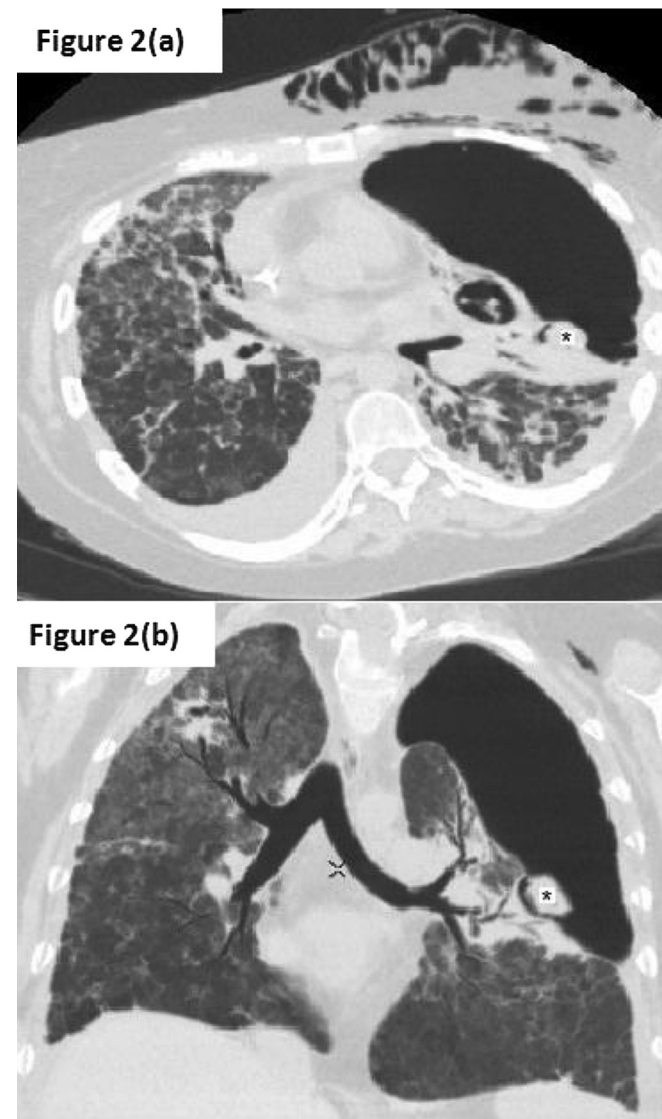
Selected axial (a) and coronal (b) images from a Thoracic Computed Tomography (CT) scan acquired on Day 96 in a patient with Invasive Pulmonary Aspergillosis (IPA). There is a left-sided tension pneumothorax and subcutaneous emphysema due to a large alveolar-pleural fistula resulting from rupture of a fungal mass lesion (*).
